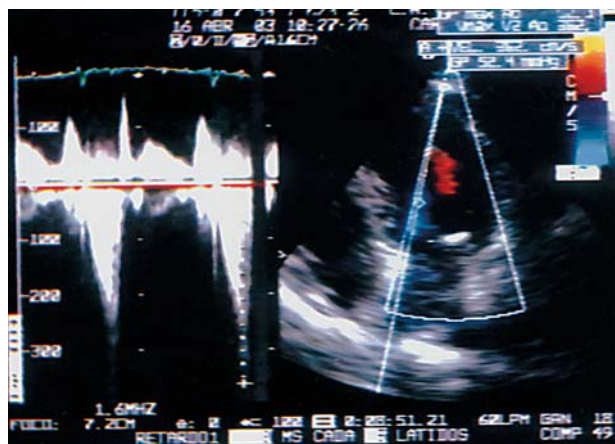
Transthoracic echocardiography image shows a dynamic subaortic gradient.
